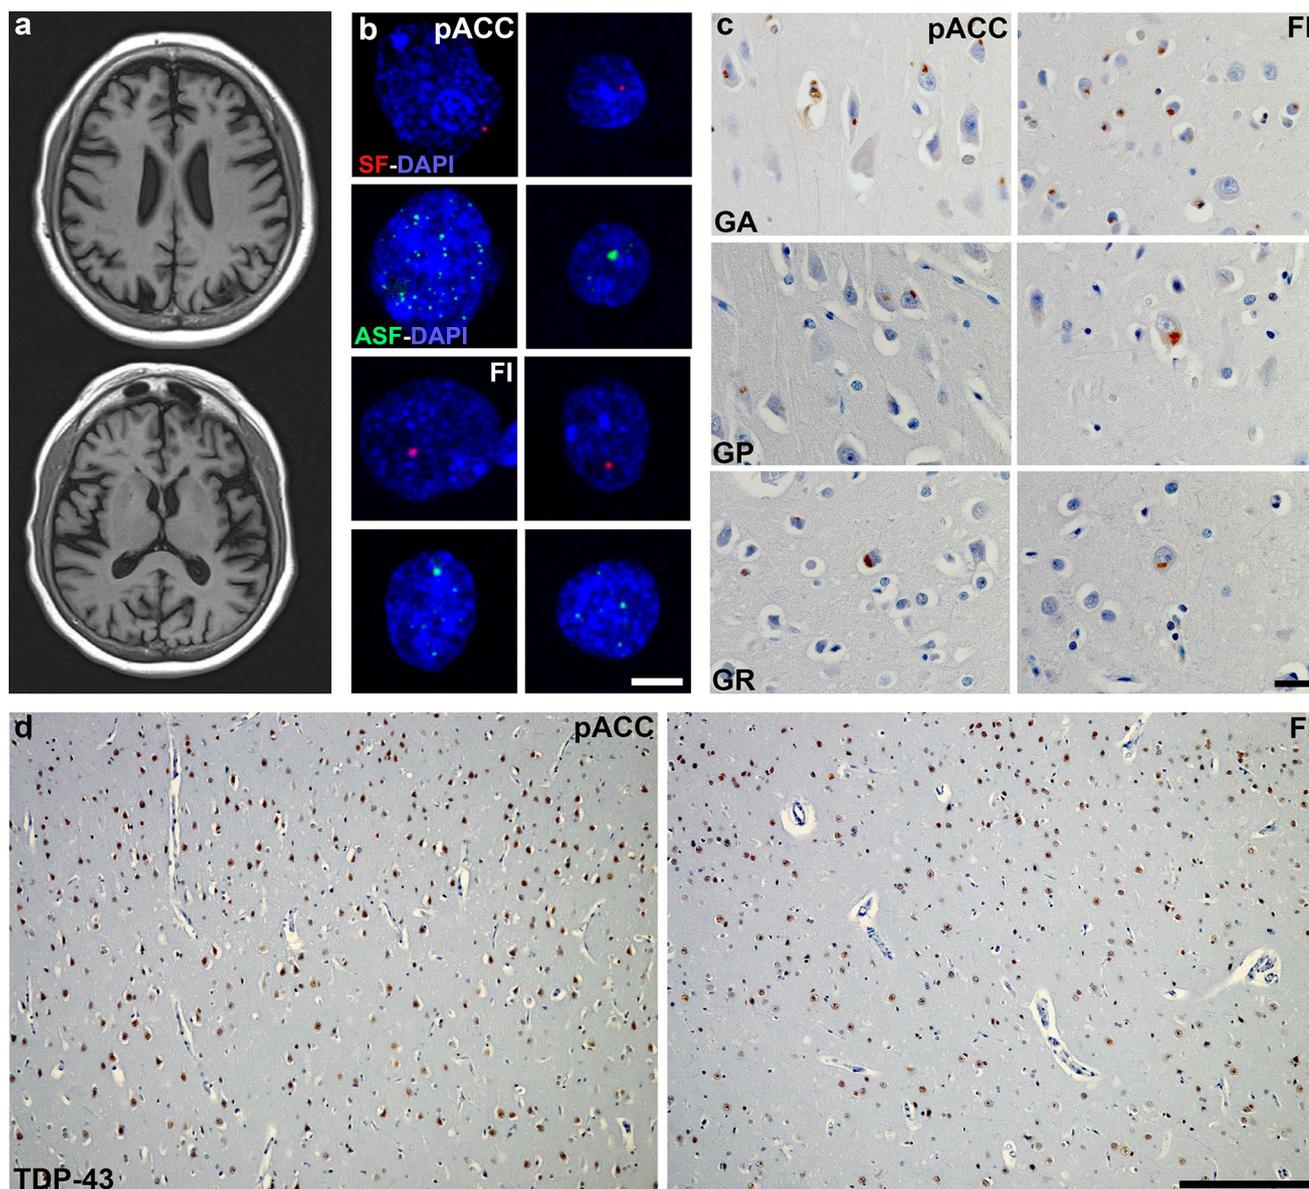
A *C9orf72* expansion carrier without TDP-43 inclusion pathology. a Axial slices from the patient's T1-weighted MRI scan show moderate to severe atrophy, most prominent in the insular, frontal, and parietal brain regions. b–d Representative images showing the presence of *C9orf72*-specific phenomena such as RNA foci and DPR inclusions in affected brain regions, including the pACC
